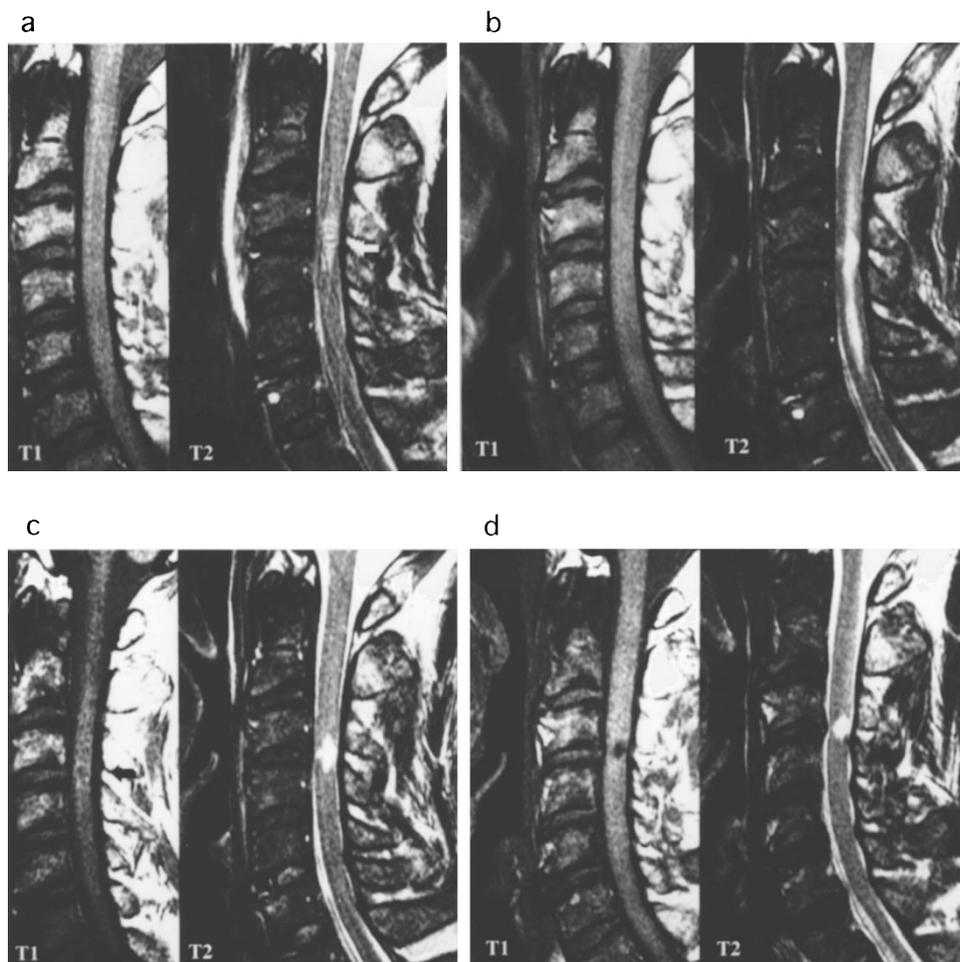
A 35-year-old man. Paralysis was grade B in the acute stage and recovered to grade D by 12 months after injury. (a) MRI at 14 h after injury. T2-weighted images showed an extensive and indistinct high signal intensity area at the C3–4 disc level (white arrow). T1-weighted images showed no signal changes. (b) MRI at 3 weeks after injury. An extensive and distinct high signal intensity area was observed on the T2-weighted image, and T1-weighted images showed no signal change. (c) MRI at 5 weeks after injury. A clear and well-defined high signal intensity area was observed at the C3–4 disc level on T2-weighted images. T1-weighted images showed a circumscribed low intensity area at the same level (black arrow). (d) MRI at 6 months after injury. The signal changes were more distinct on both T1 and T2-weighted images
